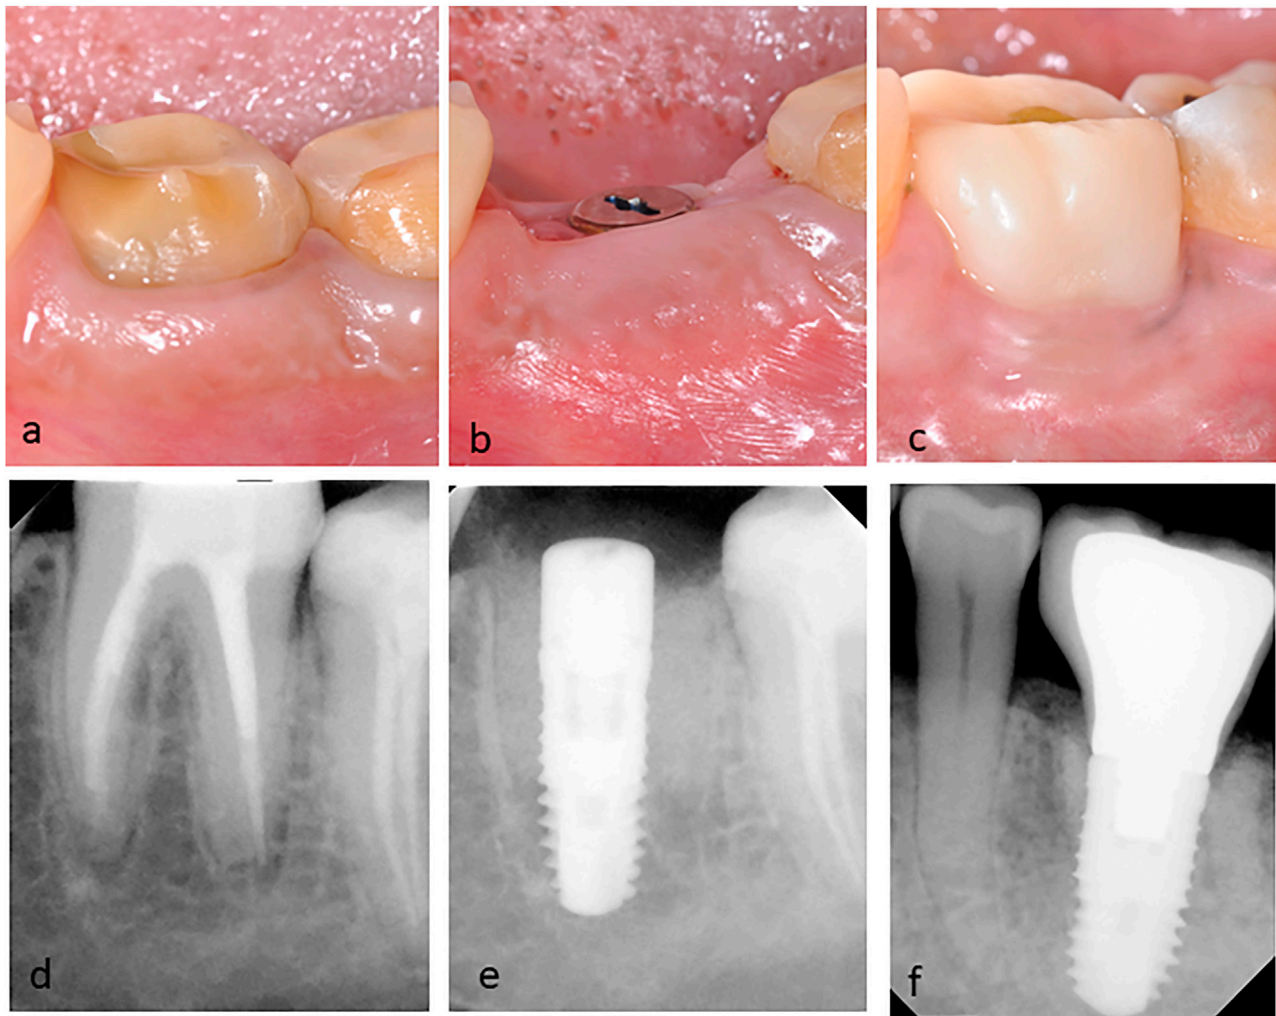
Clinical and radiographic images of the mandibular left first molar with failed endodontic treatment. (A) Preoperative clinical lateral view; (B) postoperative clinical lateral views after 3 months of implant placement; (C) clinical picture of definitive porcelain fused to the metal screw-retained implant crown at three-year follow-up; (D) Preoperative periapical radiograph; (E) periapical radiographs of the implant after 3 months; and (F) radiographic image at three-year follow-up showing the marginal bone level.
